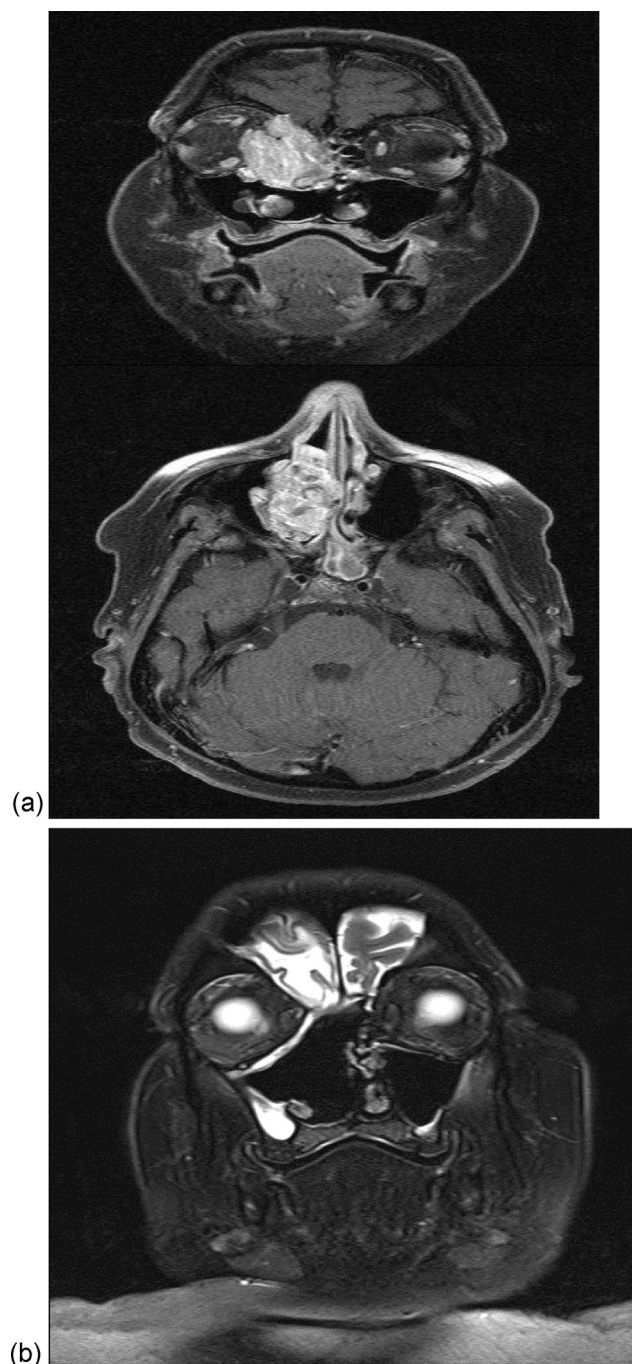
(a) Preoperative MRI (T1 sequence with gadolinium injection) showing the tumour in the right nasal fossa with intracranial extension with mass effect on the orbit. (b) Post operative MRI (T2 sequence with gadolinium injection) at 5 years showing no evidence of tumour recurrence.
